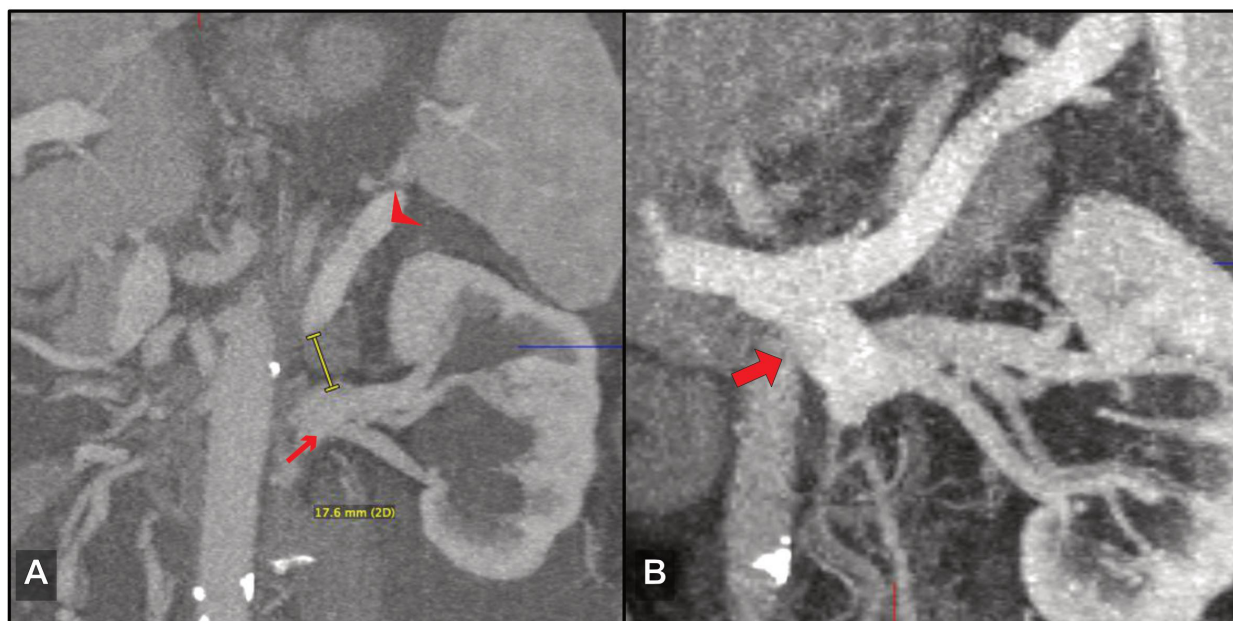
71-year-old male patient with excessive ascites after extended right hemihepatectomy (diagnosis: intrahepatic cholangiocarcinoma) – PSSS: splenorenal side-to-side; A: Preoperative CT, oblique MIP reconstruction; B: Postoperative CT, oblique MIP reconstruction; Small arrow: Left renal vein, Arrowhead: Splenic vein, Bold arrow: Splenorenal anastomosis (Reprinted with permission from Fehrenbach U, Gül-Klein S, de Sousa Mendes M, et al. Portosystemic shunt surgery in the era of TIPS: imaging-based planning of the surgical approach. *Abdom. Radiol.* (2020))
